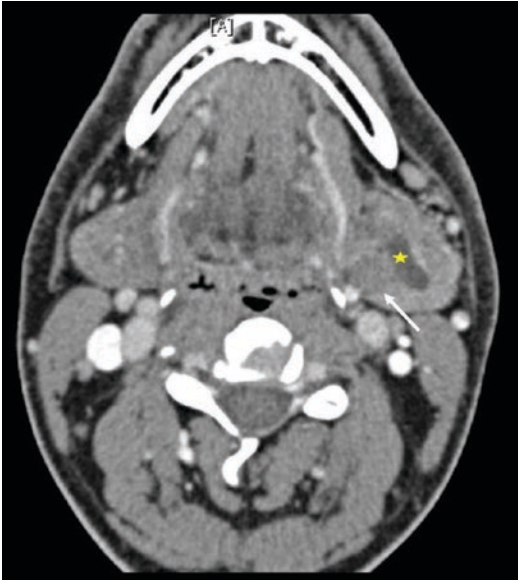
Axial CT scan showing a dilated left submandibular duct post-stone removal (indicated by *yellow asterisk*) with a hypo lucent mass in the medial and posterior aspect of the gland (indicated by *white arrow*)
